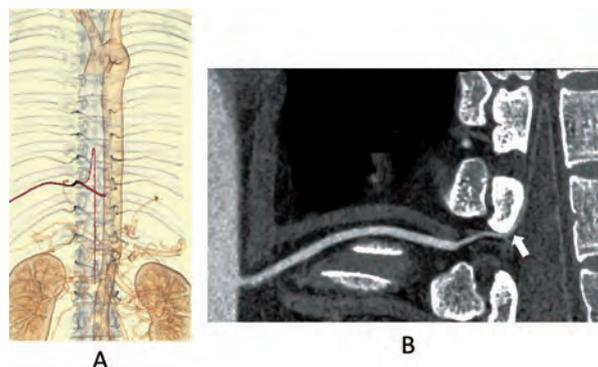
Ultra-high-resolution CT of the artery of Adamkiewicz. The volume rendering image by ultra-high-resolution CT shows the artery of Adamkiewicz in detail (A). Curved planar reformation shows the fine continuation from the intercostal artery to the artery of Adamkiewicz (B).
